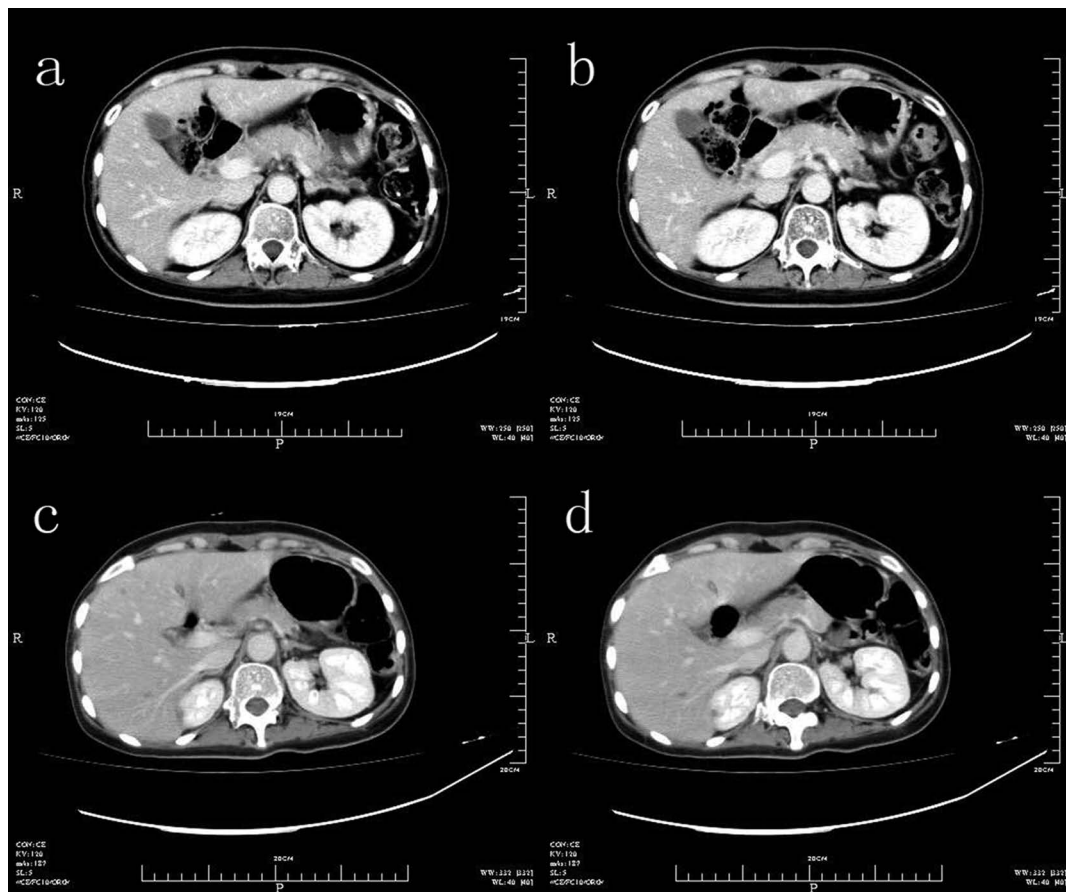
Computed tomography (CT) scan of abdomen revealed a solitary hypodensity area compared to the normal enhanced pancreas in the body of the pancreas. Before treatment with ceritinib (a, b) the metastatic lesion was 2.5×1.5 cm, while after 12 weeks of treatment with ceritinib it was about 0.8 cm (c, d).
